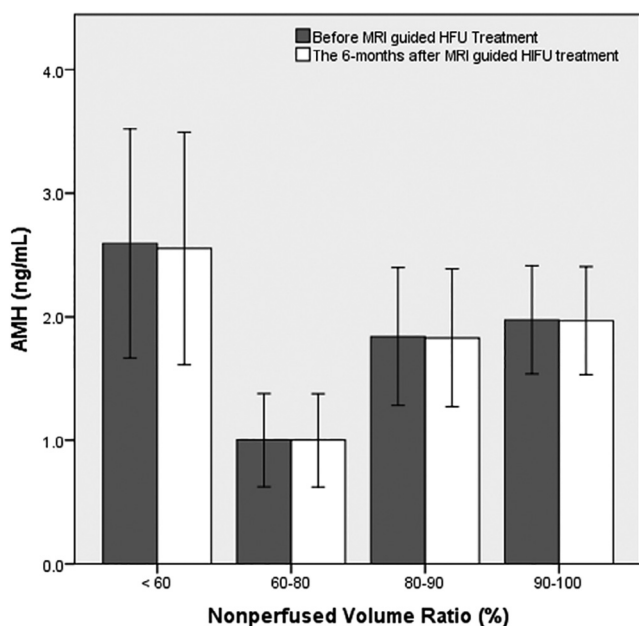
The box plot represents the serum AMH levels before and 6 months after MRI-guided HIFU treatment according to the NPV ratio of at least 90%, less than 90% but at least 80%, less than 80% but at least 60%, and less than 60%. Data are given as box-and-whisker plot. AMH, anti-Müllerian hormone; HIFU, high-intensity focused ultrasound; MRI, magnetic resonance imaging; NPV, nonperfused volume.
